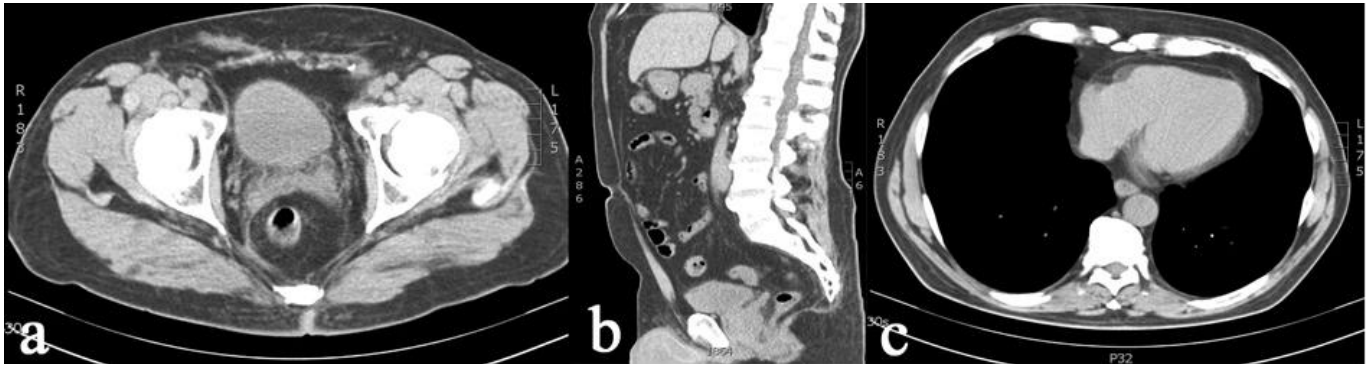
CT scan after 4 months: absence of air in the soft tissues.
